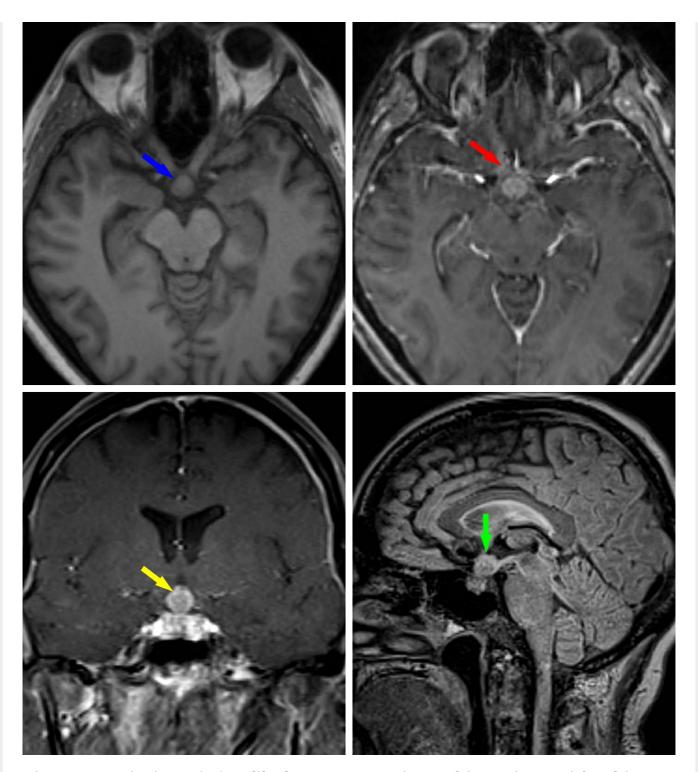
Pituitary infundibulum metastasis. In this patient with a history of breast cancer, there is evidence of a pituitary infundibulum metastasis. (Top Left) Mass-like enlargement of the pituitary infundibulum is noted on precontrast axial T1-weighted imaging (blue arrow). This lesion also demonstrates avid enhancement typical of metastatic disease on postcontrast T1-weighted axial (top right, red arrow) and coronal (bottom left, yellow arrow) images. (Bottom Right) This lesion demonstrates mild FLAIR hyperintensity (green arrow), but a metastatic lesion in this location has less continuity with surrounding parenchyma, which often renders the associated vasogenic edema less conspicuous.
